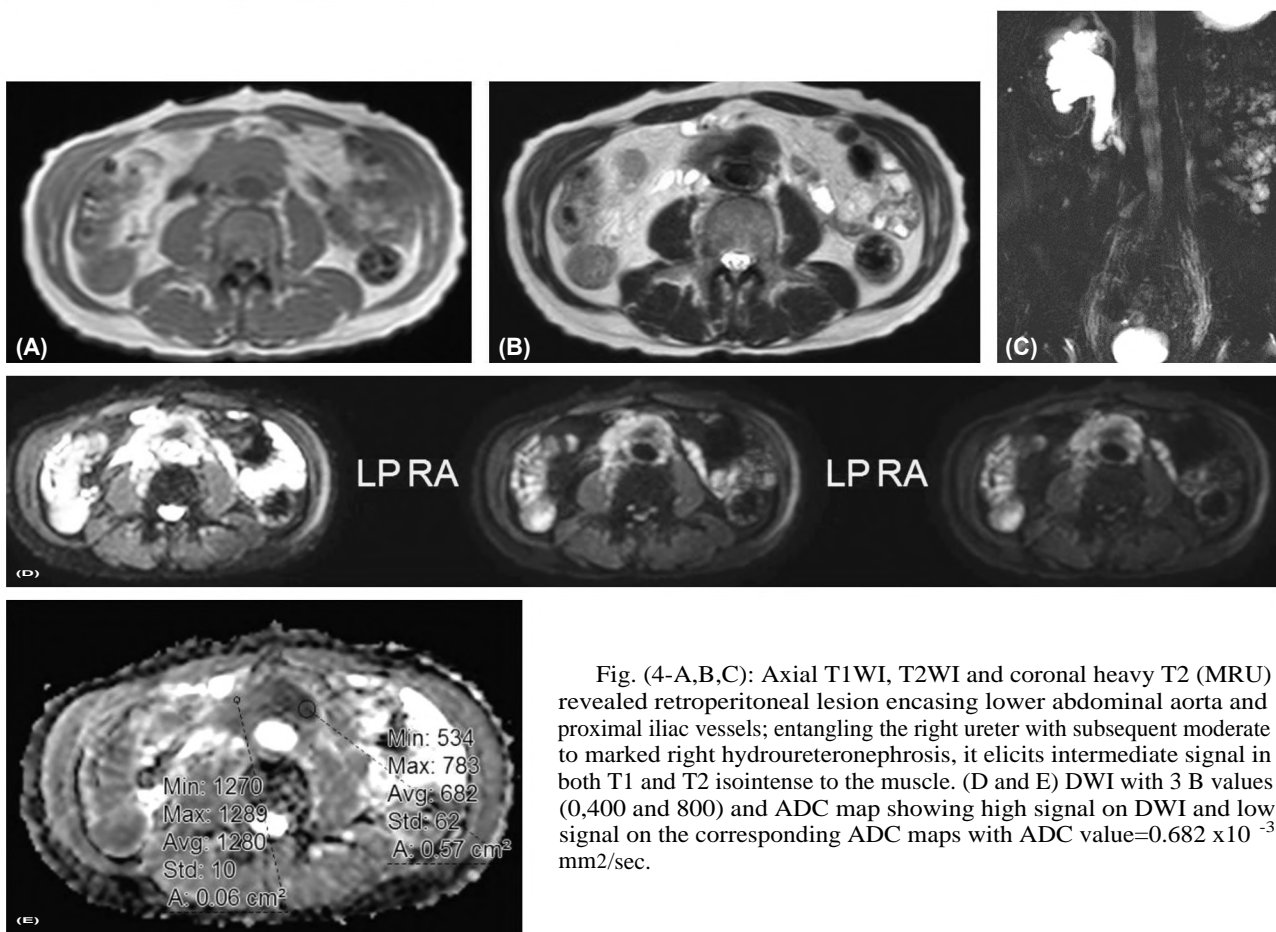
Axial T1WI, T2WI and coronal heavy T2 (MRU) revealed retroperitoneal lesion encasing lower abdominal aorta and proximal iliac vessels; entangling the right ureter with subsequent moderate to marked right hydronephrosis, it elicits intermediate signal in both T1 and T2 isointense to the muscle. (D and E) DWI with 3 B values (0,400 and 800) and ADC map showing high signal on DWI and low signal on the corresponding ADC maps with ADC value=0.682 x10⁻³ mm²/sec.
